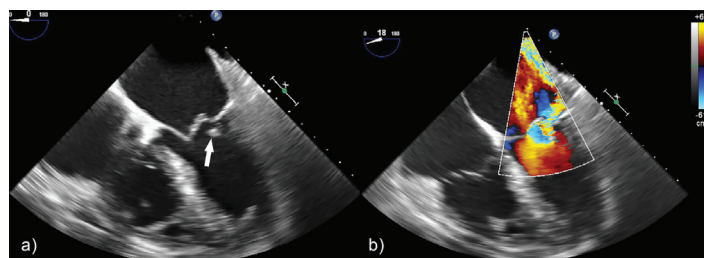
2D transesophageal long-axis view: a) arrow points to the flailing mass attached to the leaflet of the mitral valve, b) Doppler color flow mapping shows the jet of severe eccentric mitral regurgitation.
